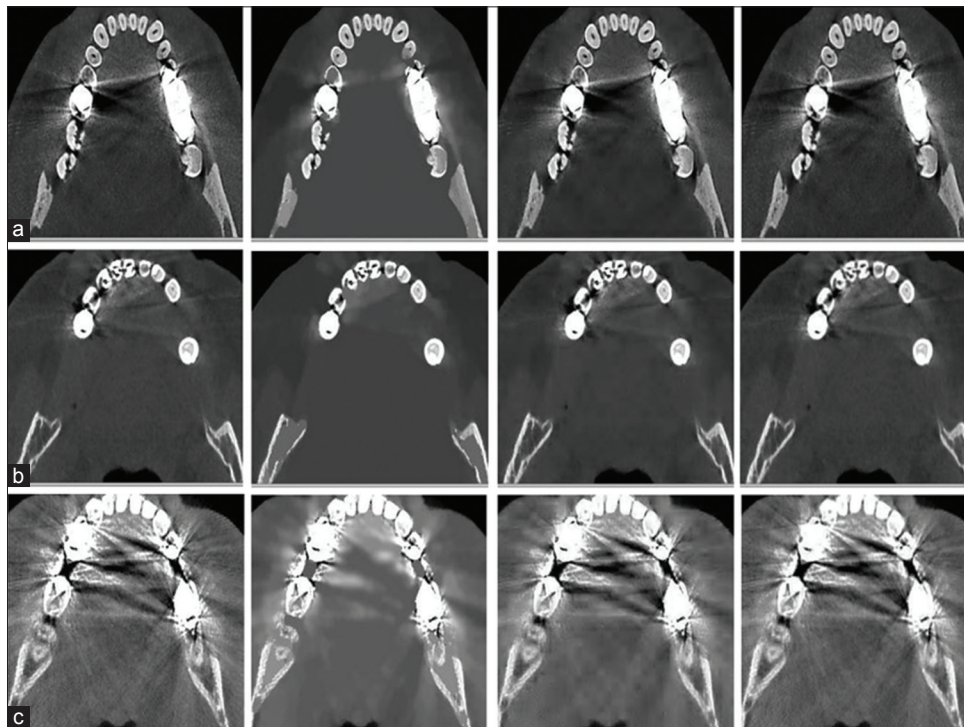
(a-c) Dental CBCT image and the result of applying artifact reduction using proposed algorithm, DWT-based noise reduction and DCT-based artifact reduction, respectively (from left to right). Comparison of proposed method with discrete wavelet transform and discrete cosine transform-based image denoising methods
